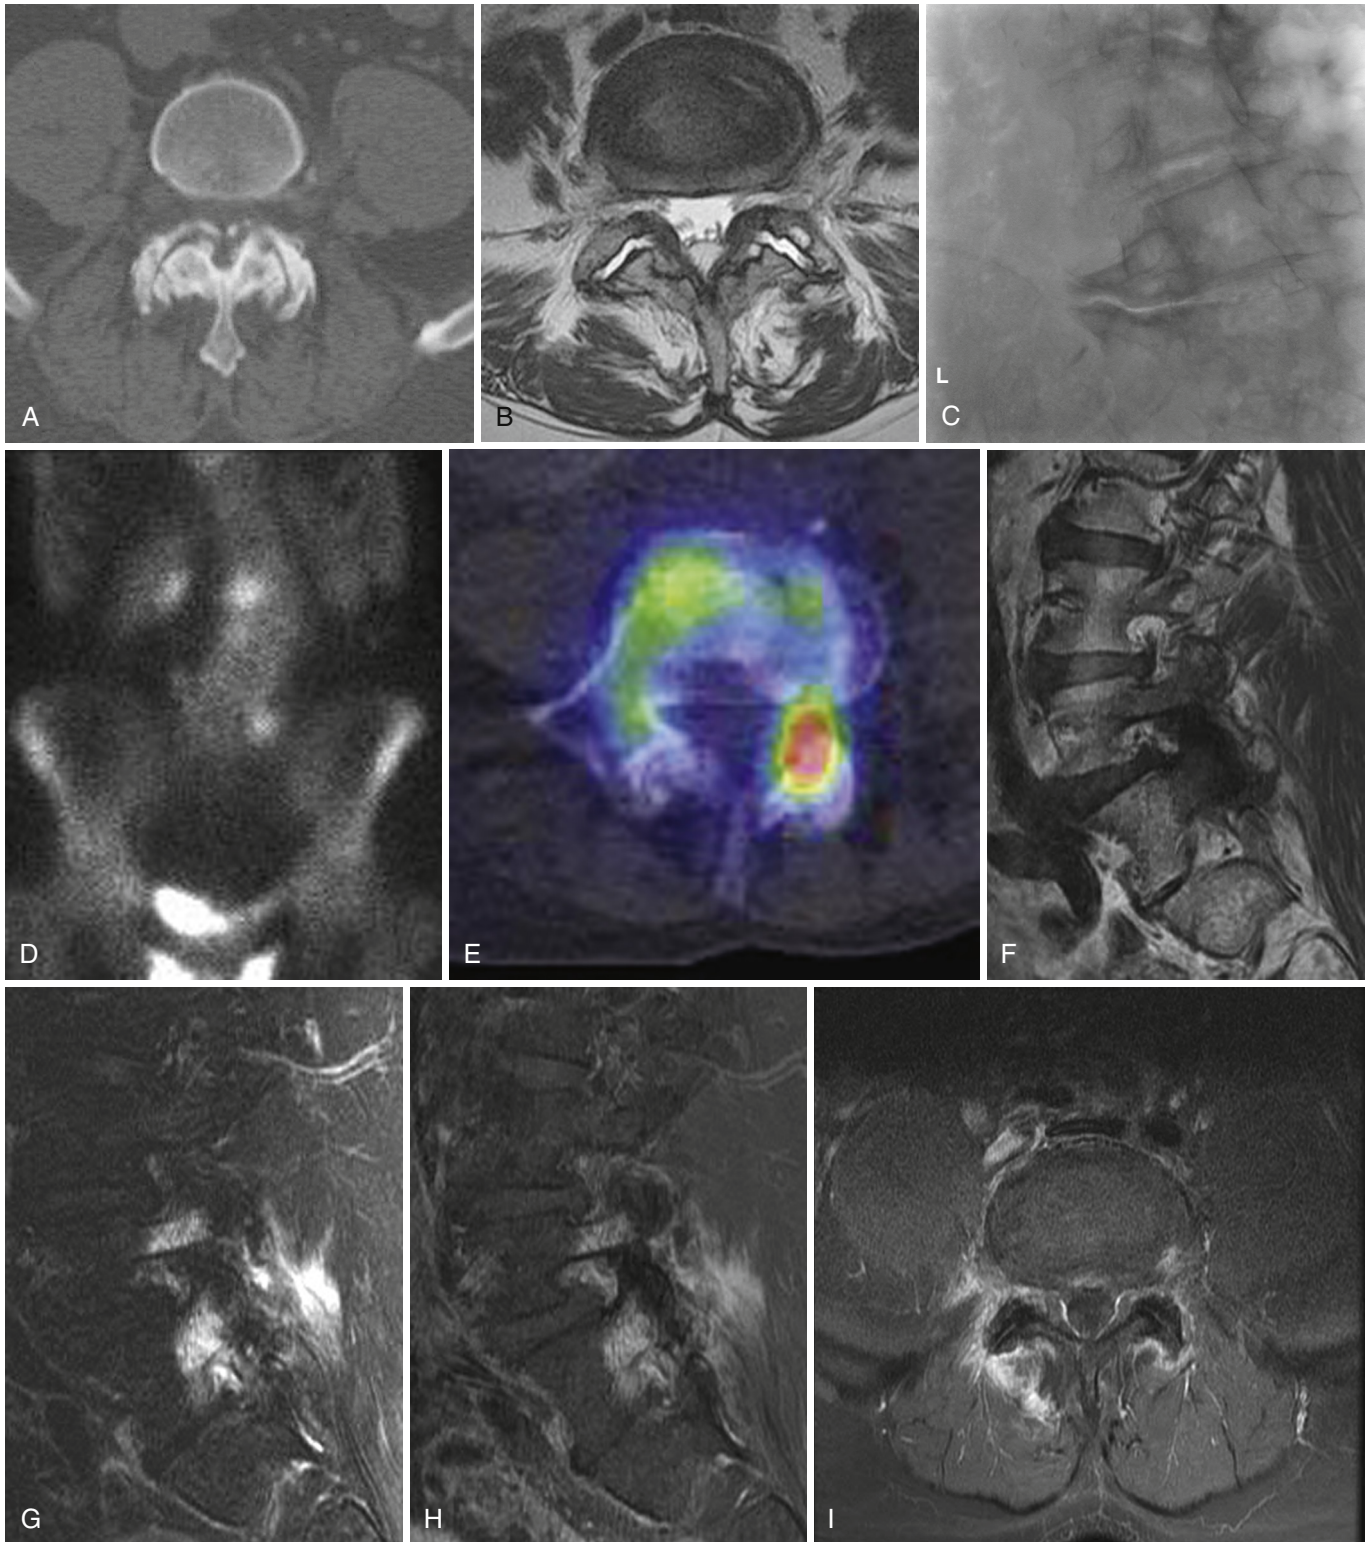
Imaging of facet arthrosis and synovitis. The changes of arthrosis (i.e., joint space narrowing, osteophytes, subchondral cysts, or sclerosis) as seen in the CT image (A) the T2 MRI image (B) or the radiographic image (C) do not correlate with pain. Planar bone scan image (D) of the same patient as (C) shows increased uptake near the lumbosacral junction on the left in this patient with left-sided axial pain. SPECT/CT image (E) provides better anatomic localization to the left L4-5 facet. In another patient with right-sided axial lumbar pain, T1 MRI image (F) shows low signal in right L5 pedicle, right L4-5 facet. Fat-saturated T2 sagittal image (G) demonstrates T2 hyperintensity in L4 and L5 pedicles, L4-5 facet, and adjacent soft tissues. Enhanced T1 sagittal (H) and axial (I) images also demonstrate the extensive inflammatory response in this patient with active synovitis. T2 hyperintensity or enhancement in pedicles can occur in facet synovitis or stress fractures of the pars or pedicle.
